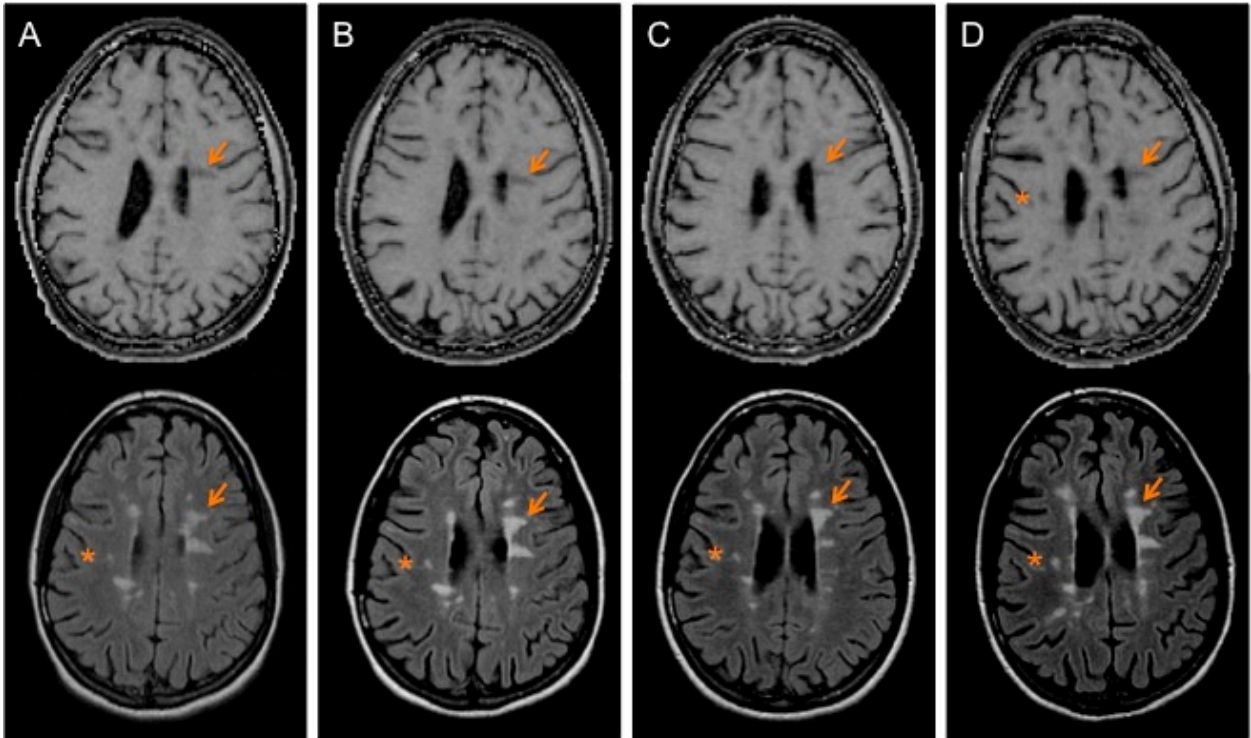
Axial MTR maps (top row) and corresponding axial FLAIR images (bottom row) of a girl who presented with a first attack of MS at age 11 years. Scans were acquired at 5 years (Panel A), 6 years (Panel B), 7 years (Panel C) and 8 years (Panel D) post-onset.
